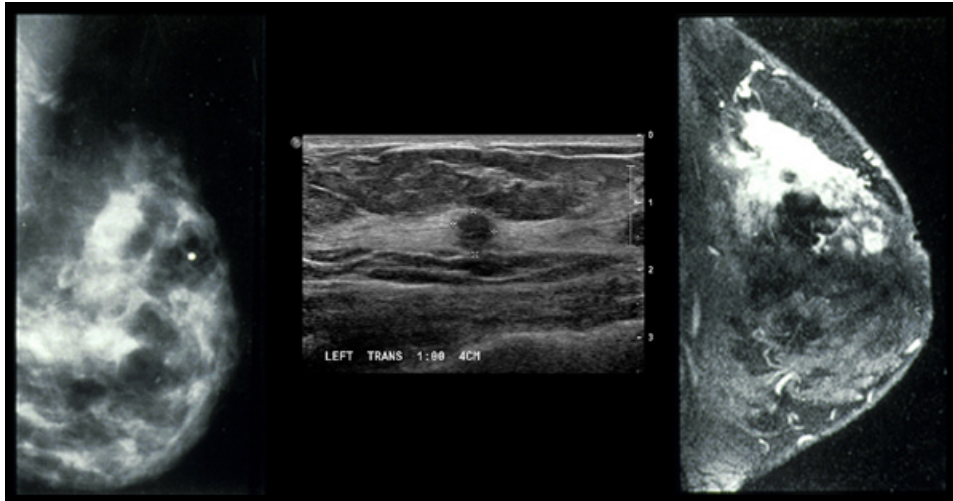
Visual comparing (in order: Mammography, Ultrasound, MRI)
